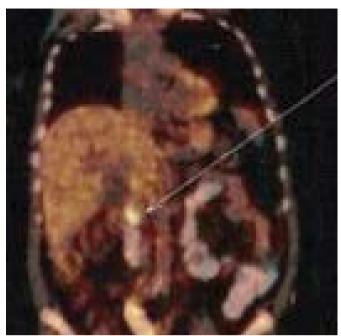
PET-CT scan showing higher uptake for the pancreatic tumor.
